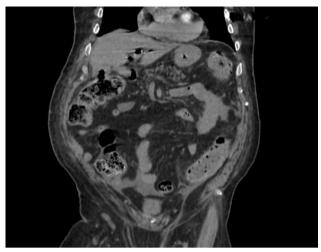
Coronal plane abdominal computed tomography (CT) scan revealing a cholecystocolonic fistula, characterized by an abnormal communication between the gallbladder and the colon.
